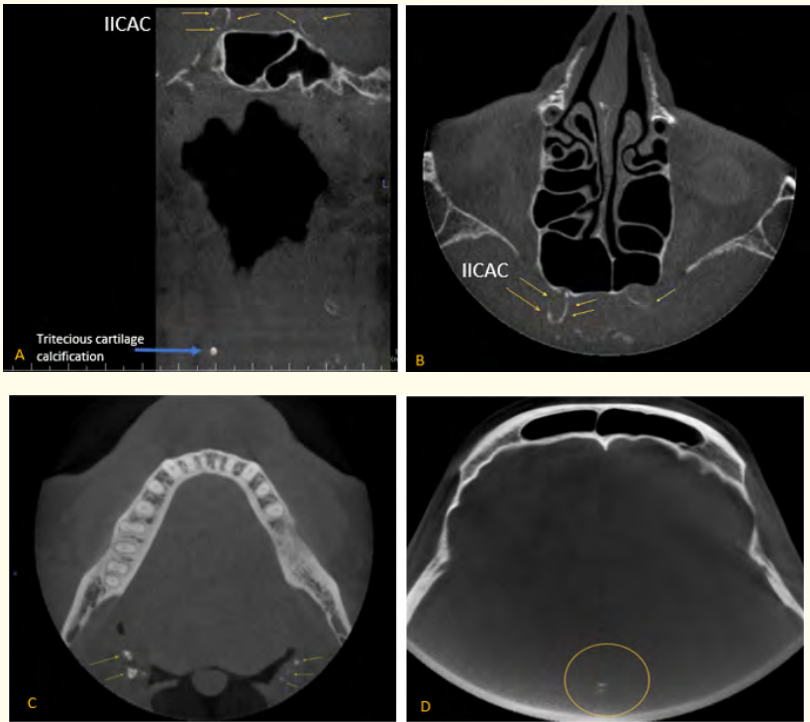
CBCT sections. A) Coronal section: Yellow fine arrows in the Sella turcica region, point to the intracranial internal carotid artery calcification (IICAC), while the blue arrow in the soft tissue lateral to the right side of the oropharynx point to the calcified triticeous cartilage. B) Axial section, yellow fine arrows in the Sella turcica region, point to the intracranial internal carotid artery calcification (IICAC). C and D are axial sections with the yellow fine arrows in the oropharynx pointing to multiple, irregular shaped calcified structures bilaterally distributed in the oropharynx consistent with tonsilloliths and yellow ring encircling the pineal gland calcification respectively.
